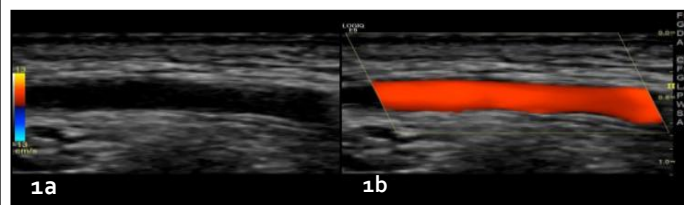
Longitudinal view of normal superficial temporal artery (TA). 1b: Longitudinal view of normal TA with colour Doppler. 1c: Transverse view of normal parietal artery (left). The vessel compresses fully and is non visible (right).
